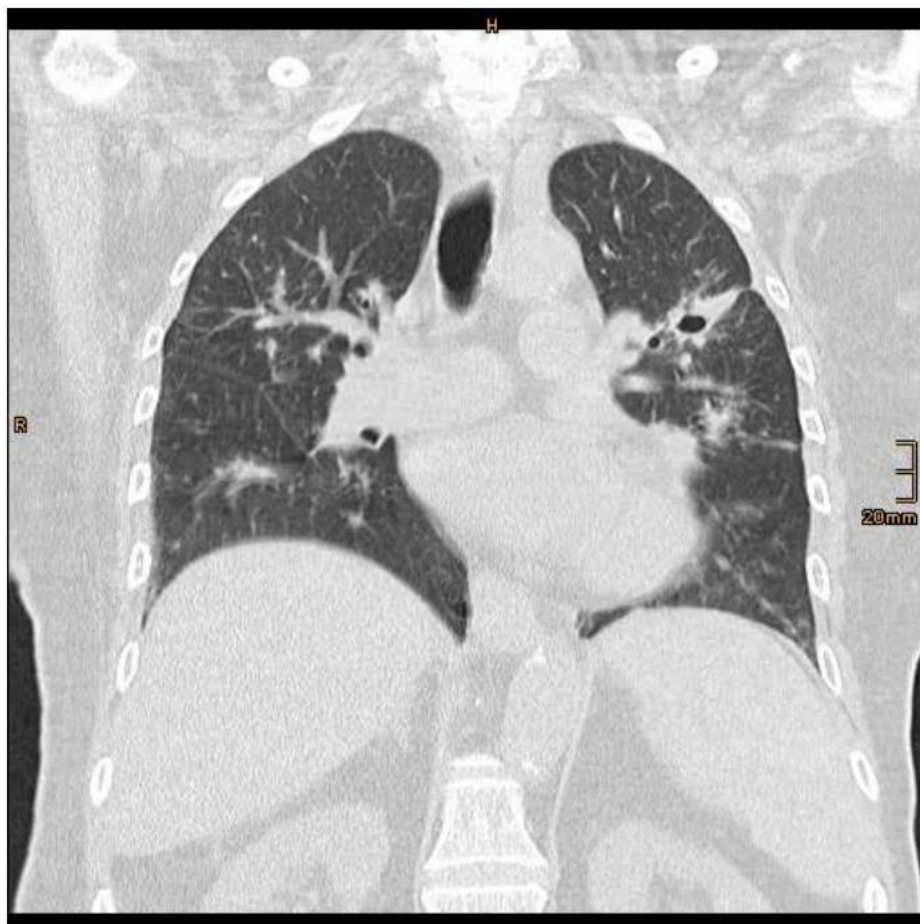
Chest CT a.p. before discharge.
